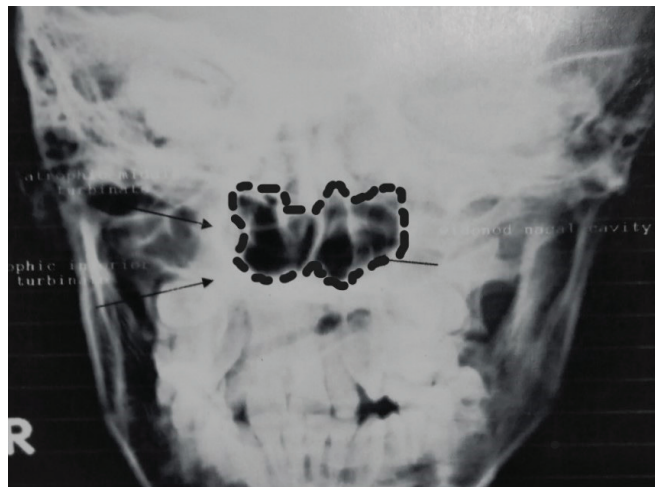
Radiolucent area in plain radiography (marked out in broken line)
